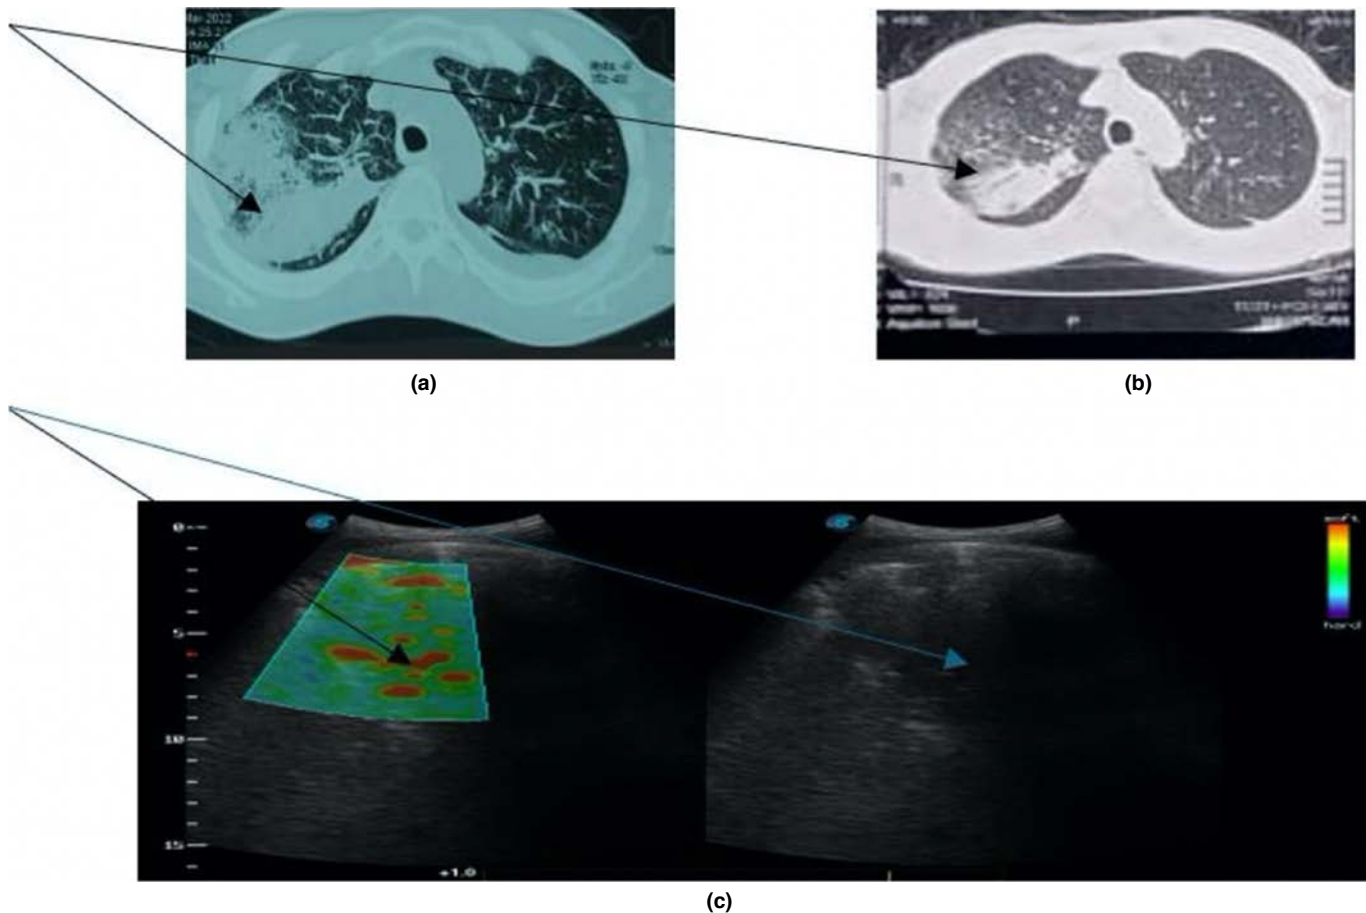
Computed tomography (CT) chest of a consolidation pre- and post-antimicrobial therapy with ultrasound elastography examination of the same lesion. Figure 5 describes a patient presenting with high-grade fever, productive cough with hemoptysis, and right-sided chest pain. (a) Initial chest CT scan (lung window) upon admission showed extensive right upper consolidation with air bronchogram. (b) A follow-up CT scan after antimicrobial therapy demonstrated significant regression of the consolidation, aligning with clinical improvement and a marked decrease in C-reactive protein (CRP) levels. (c) Ultrasound elastography (USE) with a strain ratio (SR) of 0.12 and B-mode ultrasound imaging revealed an echogenic air bronchogram, while the corresponding elastography image displayed no blue component, indicating that the lesion was relatively soft, represented in red
